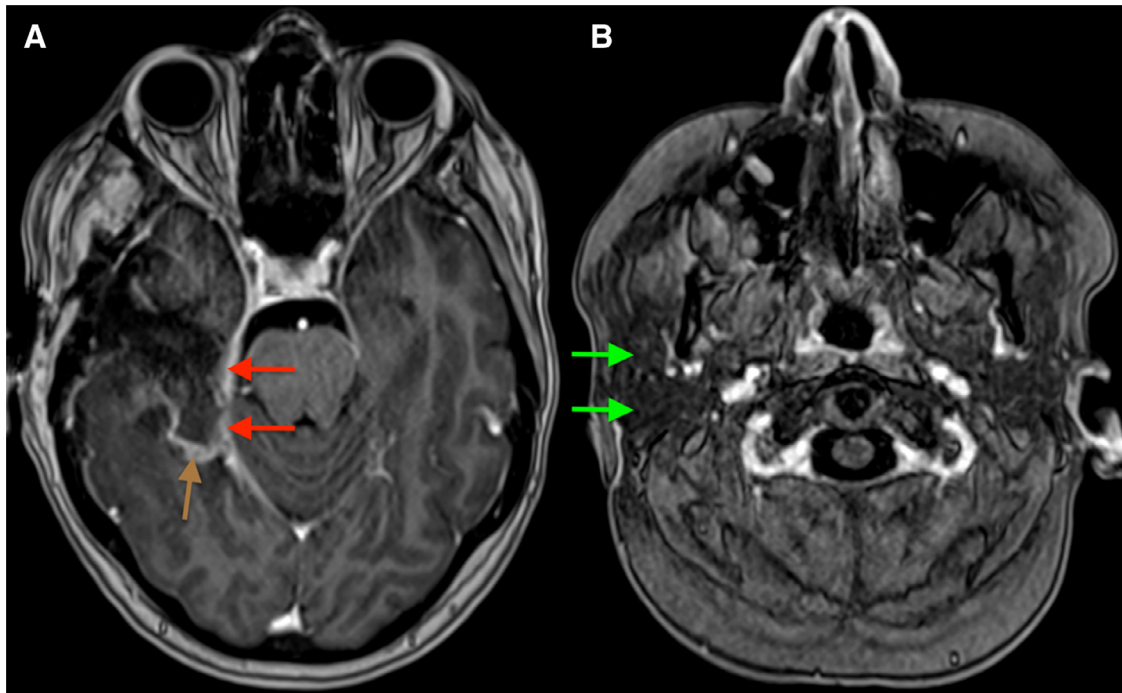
Gadolinium-enhanced T1-weighted imaging 72 hours after resection. (A) At the level of the resection cavity, subtle nodular thickening of the right tentorium cerebelli was noted (red arrows), compatible with granulation tissue or residual tumor. Residual blood products were also present (brown arrow). (B) At the level of the right parotid gland (green arrows), no enhancing lymph nodes were present.
